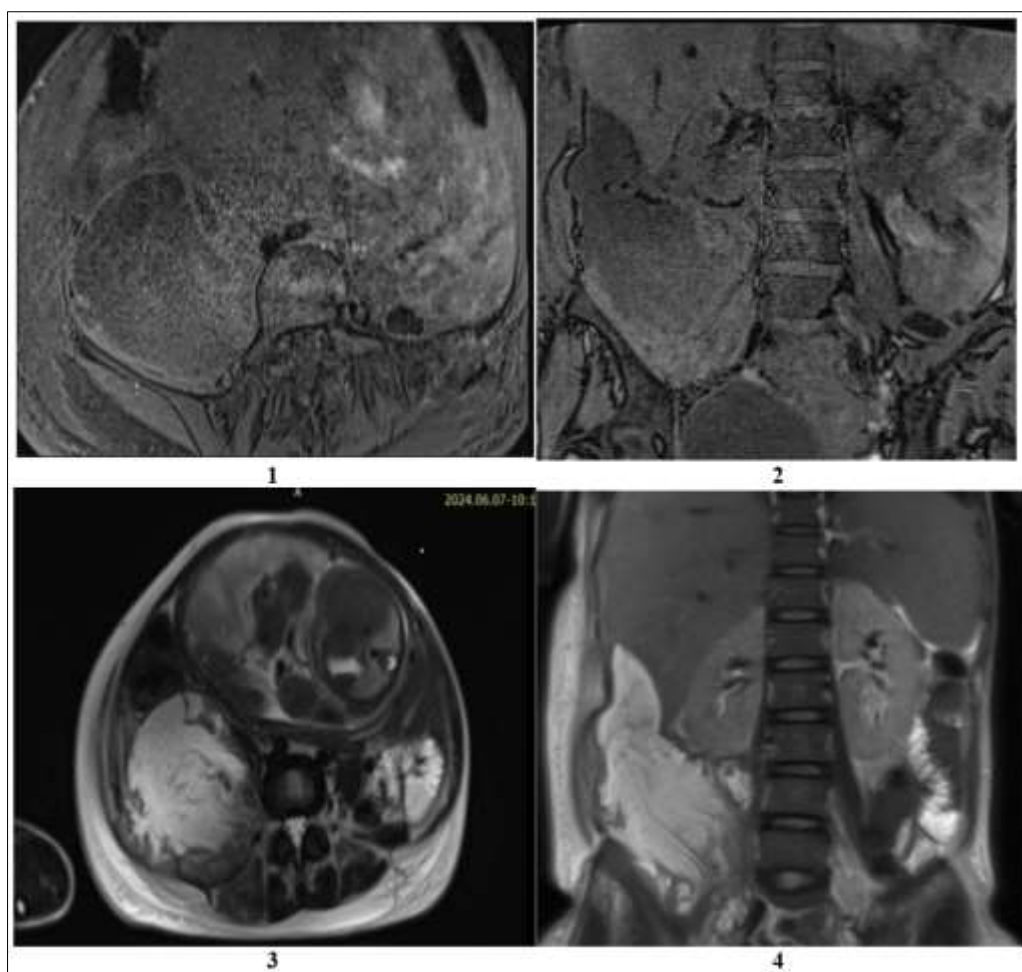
A pelvic MRI revealing a multiloculated collection in the right iliopsoas muscle, fairly well-defined, extending to the peri- and subhepatic regions. It appeared hypointense on T1 (1), (2) and heterogeneously hyperintense on T2 sequences (3), (4), measuring 10 x 9.3 x 18.2 cm (AP x T x CC).
